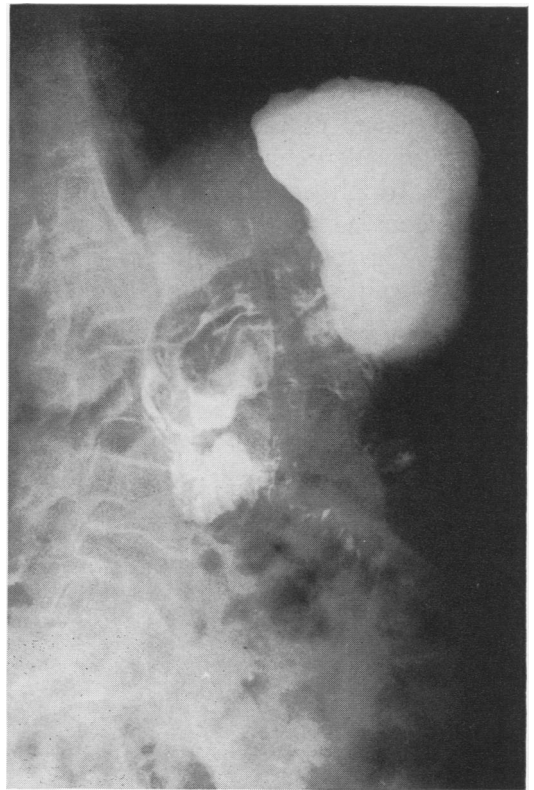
Postoperative gastrointestinal x-ray after extensive resection of duodenal wall and reconstruction with method outlined (Case 3).
